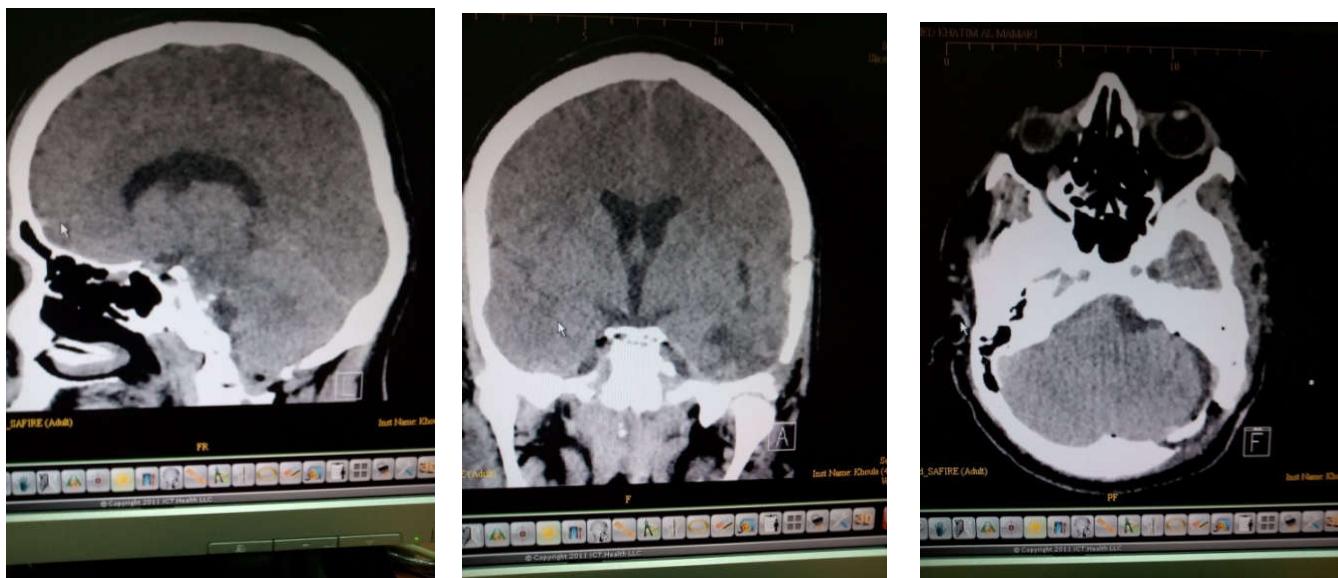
CT brain after 2 nd stage surgery
